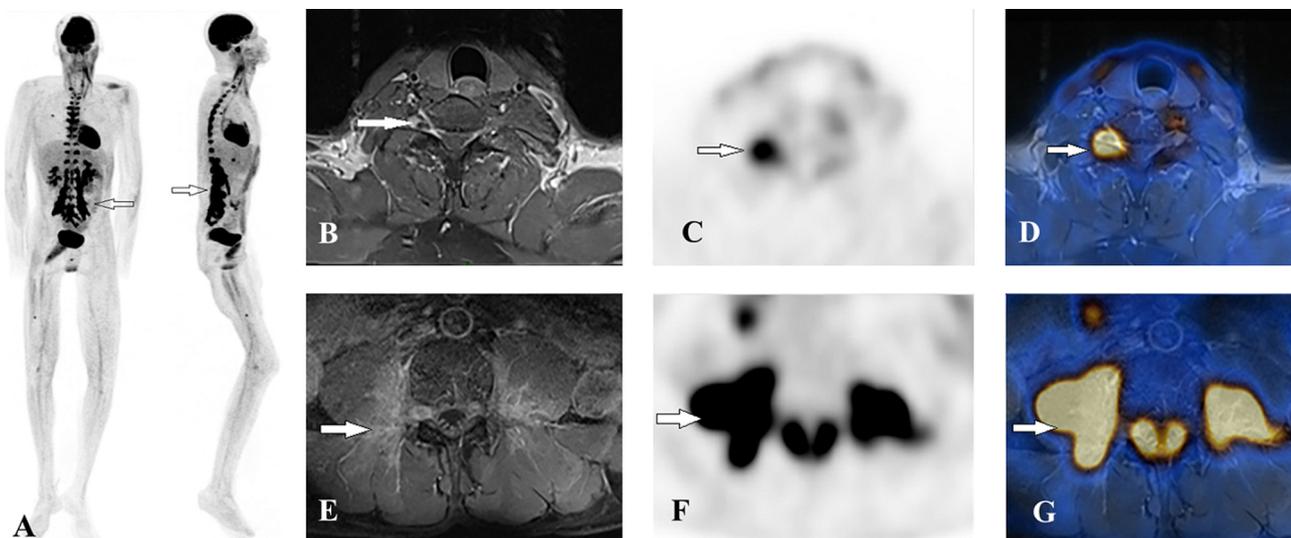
70-year-old man with untreated HIV infection presenting with diffuse neurolymphomatosis as a relapse of diffuse large B cell lymphoma. A. ¹⁸F-FDG PET/CT images in maximum intensity projection show extensive and intense ¹⁸F-FDG uptake along spinal nerve roots (arrows) from thoracic to lumbosacral vertebrae. B. Fat-suppressed T1-weighted MR image obtained in the axial plane after intravenous administration of a gadolinium chelate shows enhancement and thickening of right cervical root (arrow) at the level of the 6th cervical vertebra. C. ¹⁸F-FDG PET/CT image in the axial plane shows increased ¹⁸F-FDG uptake of right cervical foraminal root (arrow) at the same level than in B. D. Fused image from ¹⁸F-FDG PET/CT and MR data confirms cervical foraminal root location. E. Fat-suppressed T1-weighted MR image obtained in the axial plane after intravenous administration of a gadolinium chelate shows bilateral enhancement and thickening of lumbar roots (arrow) in their foraminal and extra-foraminal portions at the level of the third lumbar vertebra. F. ¹⁸F-FDG PET/CT image in the axial plane shows increased ¹⁸F-FDG uptake of lumbar roots (arrow) in their foraminal and extra-foraminal at the same level than in E. G. Fused image from ¹⁸F-FDG PET/CT and MR data confirms lumbar foraminal roots location.
